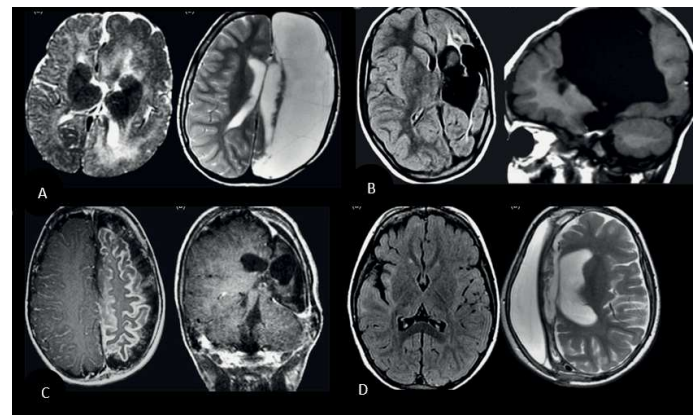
a) Hemimegalencephaly. Axial T2w MRI shows extensive growth of the left hemisphere with enlargement of the white matter throughout the hemisphere, b) left porencephalic frontotemporal cyst affecting the basal ganglia and thalamus of the left ventricle with the dilated and exvacuo sylvian fissure, c) MRI of Sturge-Weber disease, axial T1w with gadolinium with cortical gyri in atrophic cerebral hemisphere. d) Rasmussen encephalitis. Preoperative axial FLAIR images, the subcortical white matter signal areas of the right insula are intensified, temporal and frontal lobes with parenchymal gliosis, with slight hemiatrophy of the right hemisphere.
